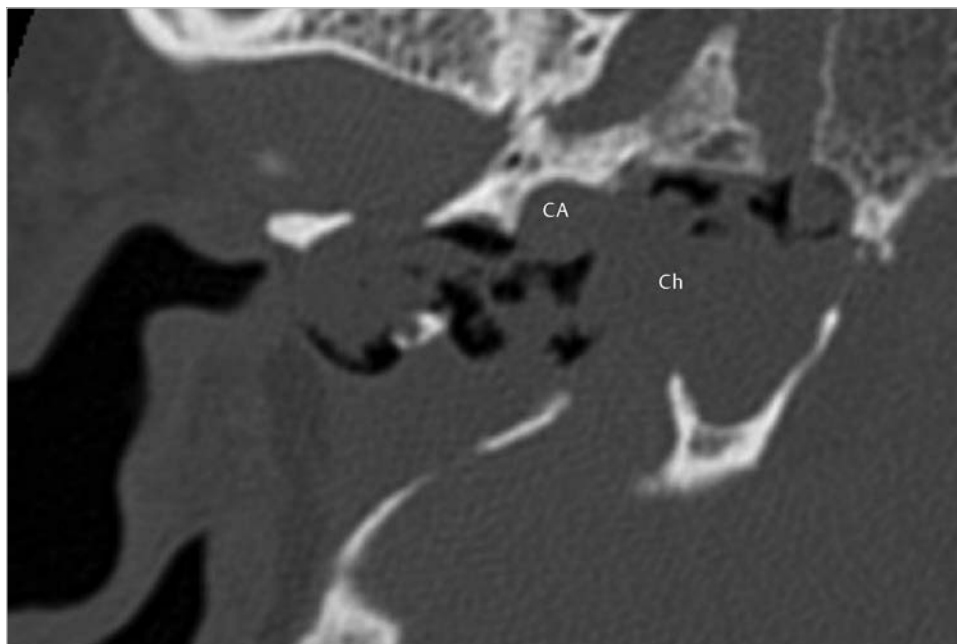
More caudal section of the CT scan is shown. The cholesteatoma (Ch) totally occupying the petrous apex, exposing the jugular bulb (JB) and the vertical segment of the carotid artery is shown. The arrow indicates skeletonized facial nerve. CA, carotid artery; Ch, cholesteatoma.
